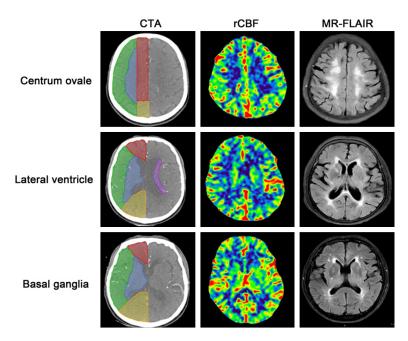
Representative images of CTA, CBF, and FLAIR. In CTA, red represents territory of ACA. Green and blue represent the territory of MCA, yellow represents PCA, blue represents the sub-cortical territory of MCA, and purple represents the territory of peri-ventricular area.
